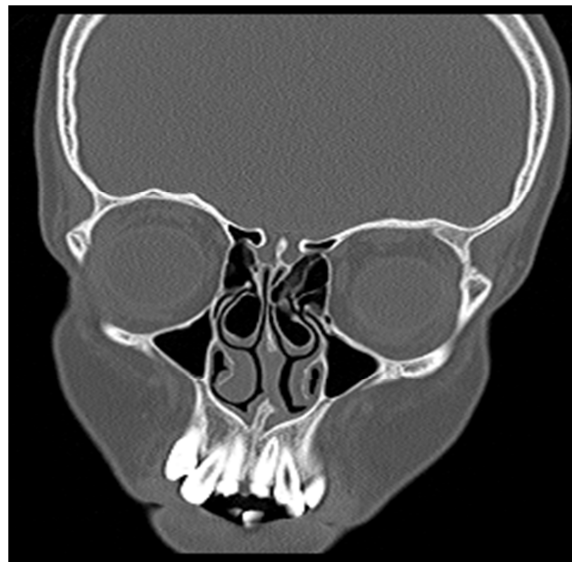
Coronal Paranasal Sinus Computed Tomography View for Bilateral Concha Bullosa
